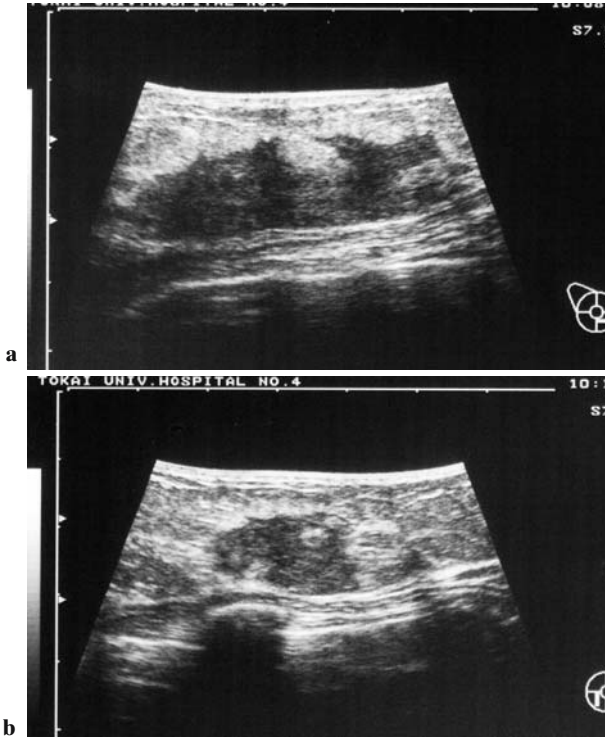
Ultrasonogram of the right (a) and left (b) sides of breast with L1 of the FAB subtype after 1 year and 6 months of bone marrow transplantation. There were hypoechoic solid masses with hyperechoic area. The posterior echo enhancement is demonstrated
